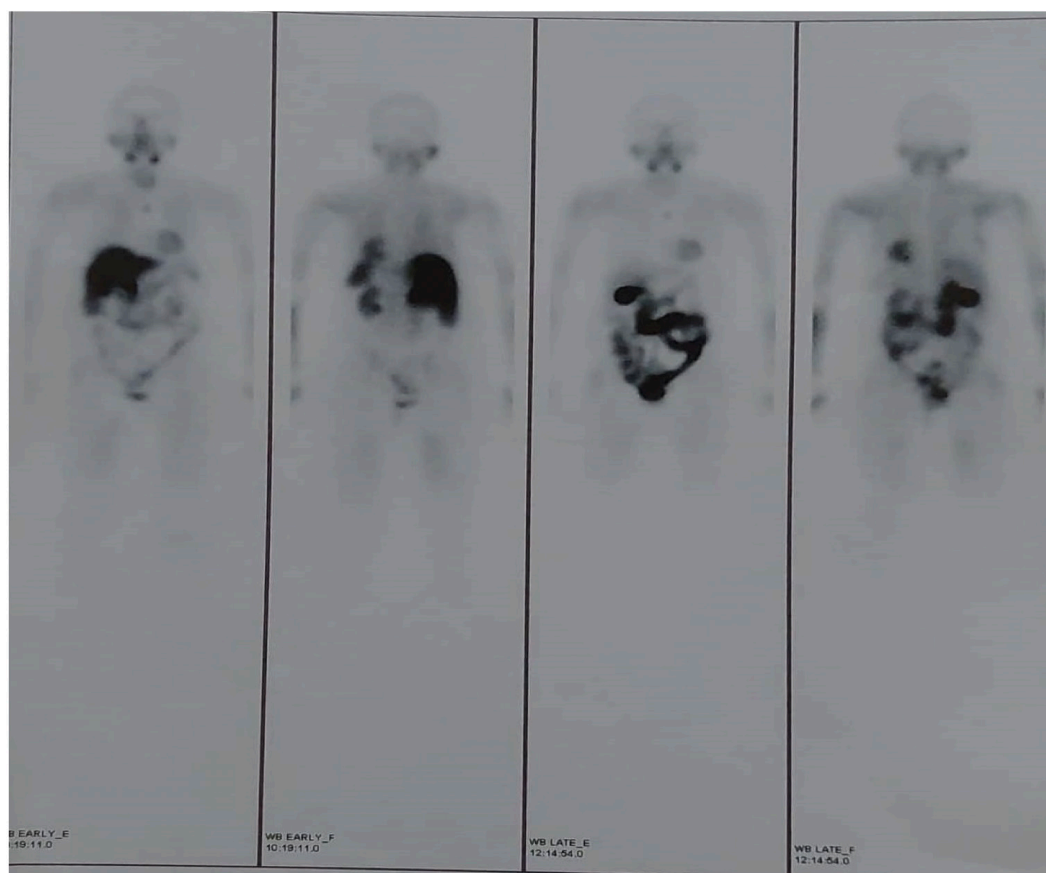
99mTc-MIBI parathyroid scintigraphy, the early (1,2) and the late (3,4) planer images.
